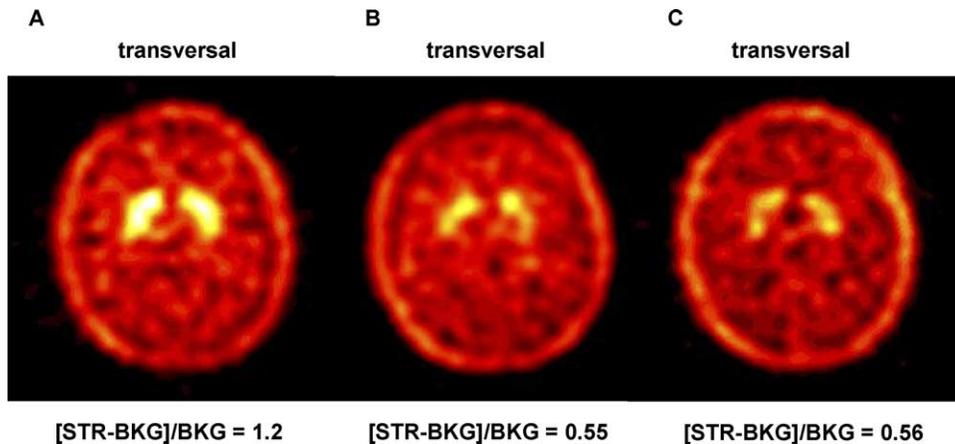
Dopamine transporter binding in the striatum of a 53 years old non-smoker before (A), after 5 h of intake of 20 mg methylphenidate (Ritalin SR®) (B), and 3 months later after 5 h of wearing a 17.5 mg/24 h nicotine skin patch (C), shown by specific accumulation of [<sup>123</sup>Tc-99m]TRODAT-1 in SPECT scans.
